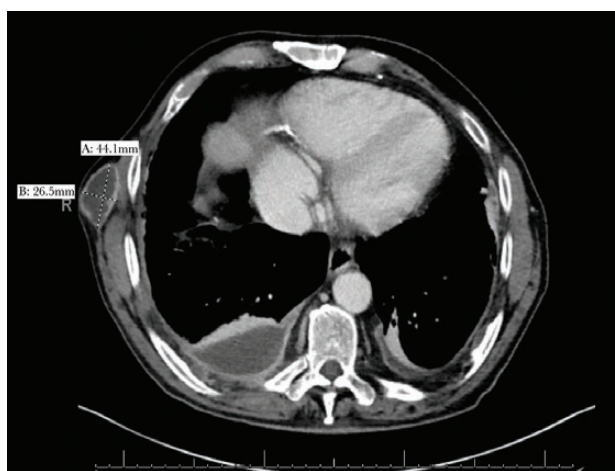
Computed tomography chest with intravenous contrast shows a complex pleural effusion, as well as radiographic visualization of the subcutaneous nodule. A, The anterior–posterior dimensions of the subcutaneous chest wall nodule. B, The medial–lateral dimensions of the subcutaneous chest wall nodule.
